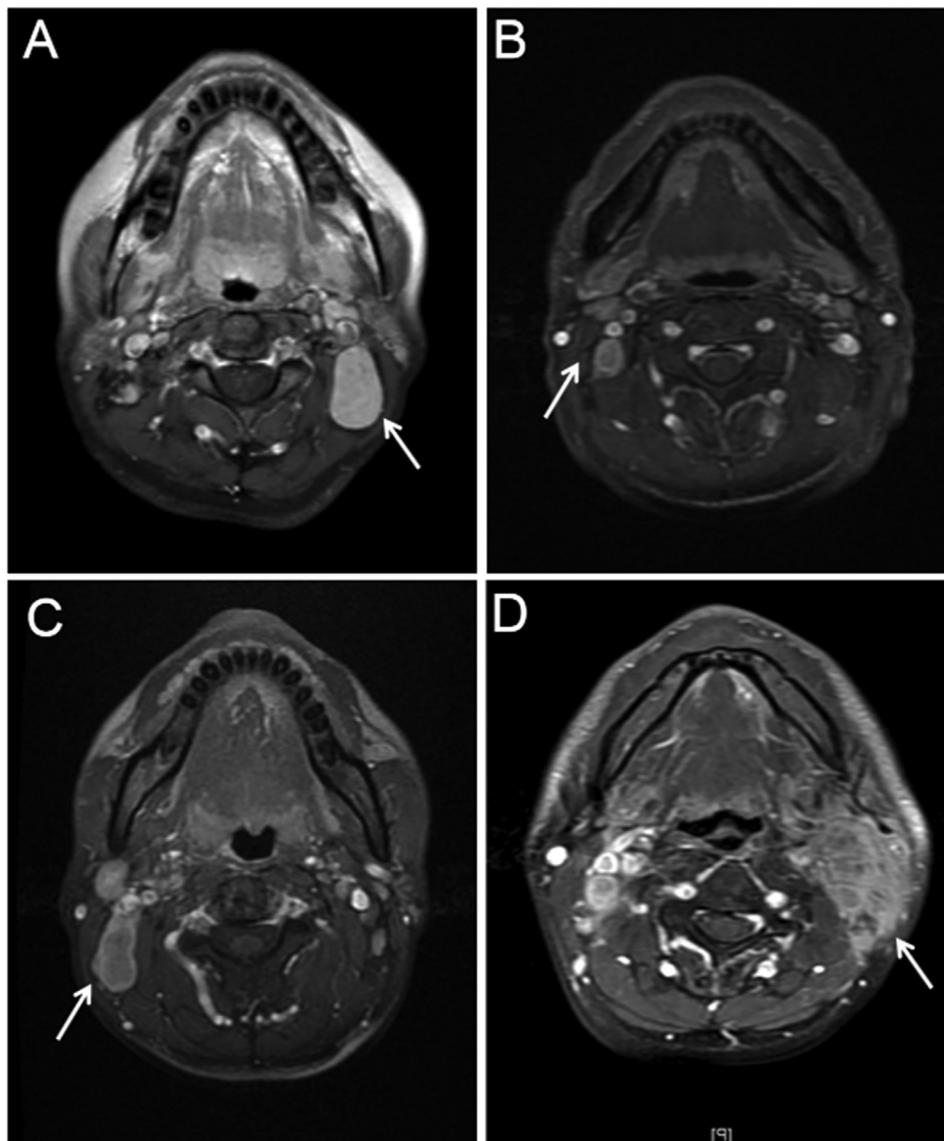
Axial T1-weighted fat-suppressed contrast MRI of NPC patients with metastatic neck nodes along internal jugular chain. (A) a metastatic node without rENE; (B) a metastatic node with rENE infiltrating surrounding fat (G1-rENE); (C) a metastatic node with coalescent LNs (G2-rENE); (D) a metastatic node with rENE infiltrating adjacent muscles (G3-rENE).
